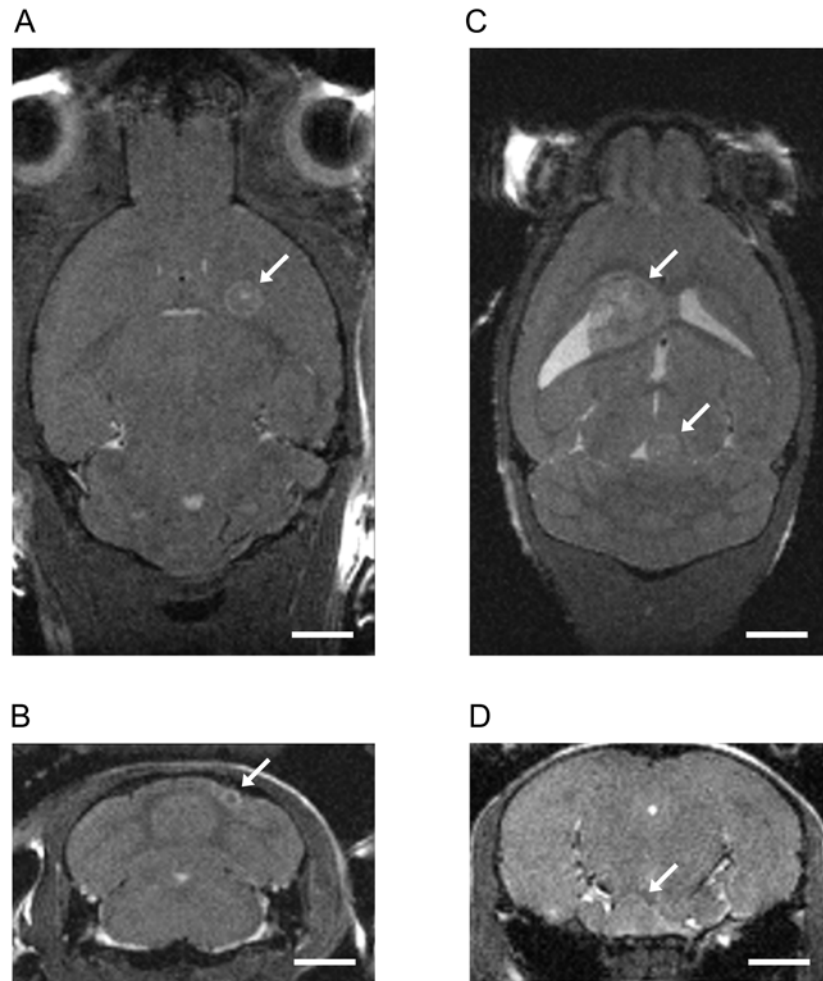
Metastatic brain tumors imaged by MRI following IV injection of BT474-Gluc cells. Intracerebral (A,B,C) and leptomeningeal metastases were detected (D). Most intracerebral metastases were located in the cerebrum (A), with occasional metastases in the cerebellum (B). Multifocal metastases were occasionally observed (C). Leptomeningeal metastases most commonly grew in the subarachnoid space (D). Scale bar, 2 mm.
